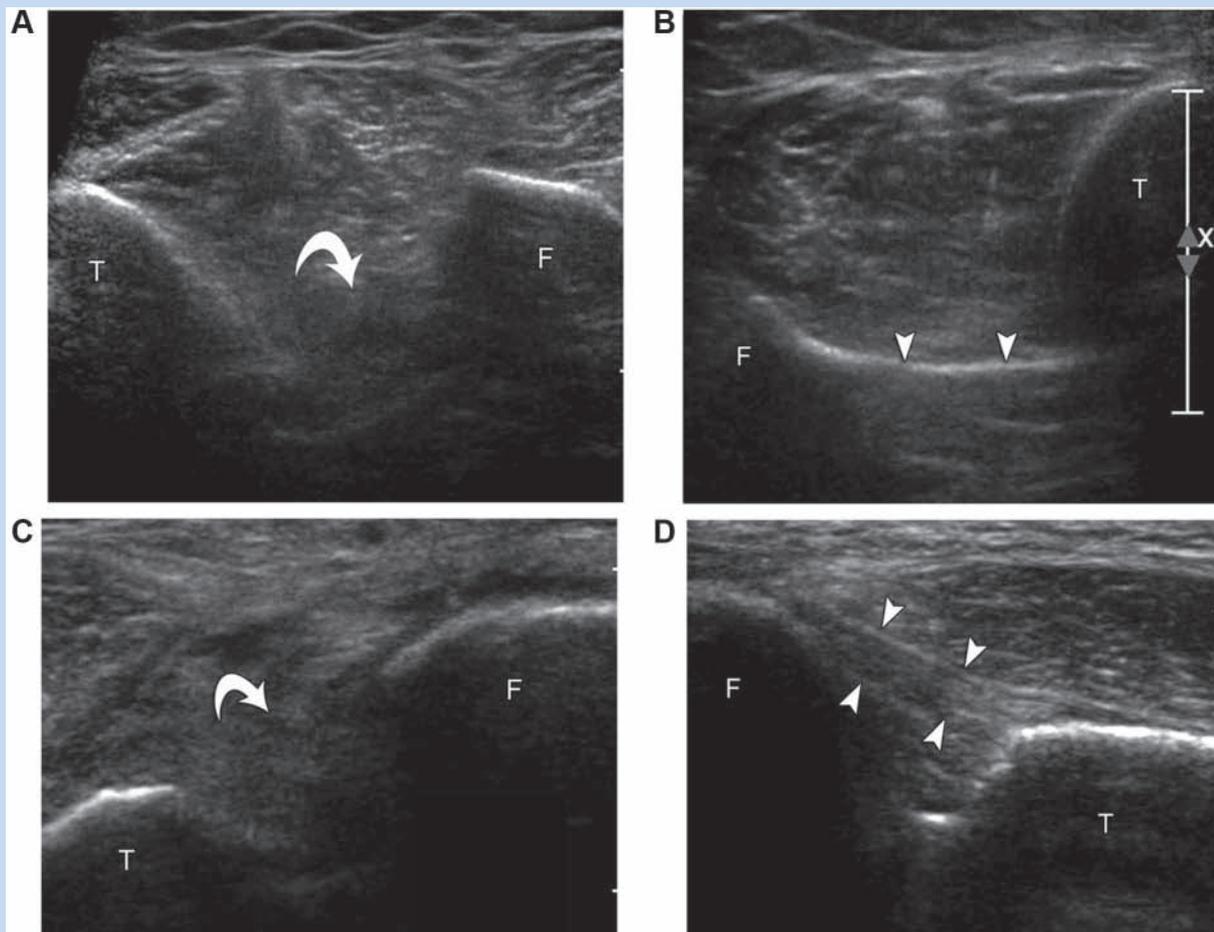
Twenty-two-year-old man with high ankle sprain. (A) Axial ultrasound image over anterior lower leg shows absence of interosseous membrane and abnormal hypoechoogenicity (curved arrow). (B) Ultrasound image of contralateral side shows normal interosseous membrane (arrowheads). (C) Oblique ultrasound image long axis to anterior inferior tibiofibular ligament shows absence of normal ligament fibers (curved arrow). (D) Ultrasound image of contralateral side shows normal anterior inferior tibiofibular ligament (arrowheads). T, tibia; F, fibula.
